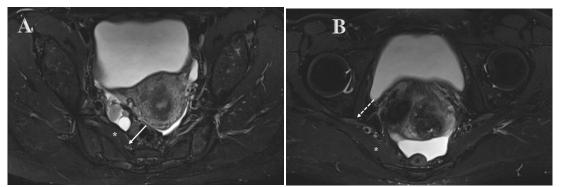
MRI pelvis T2 weighted fat suppression images at (A) S2 level and (B) S4 level in axial view showing no abnormal signal of the right S2 nerve (solid arrow), right sciatic nerve (dashed arrow), and right piriformis muscle (*).
